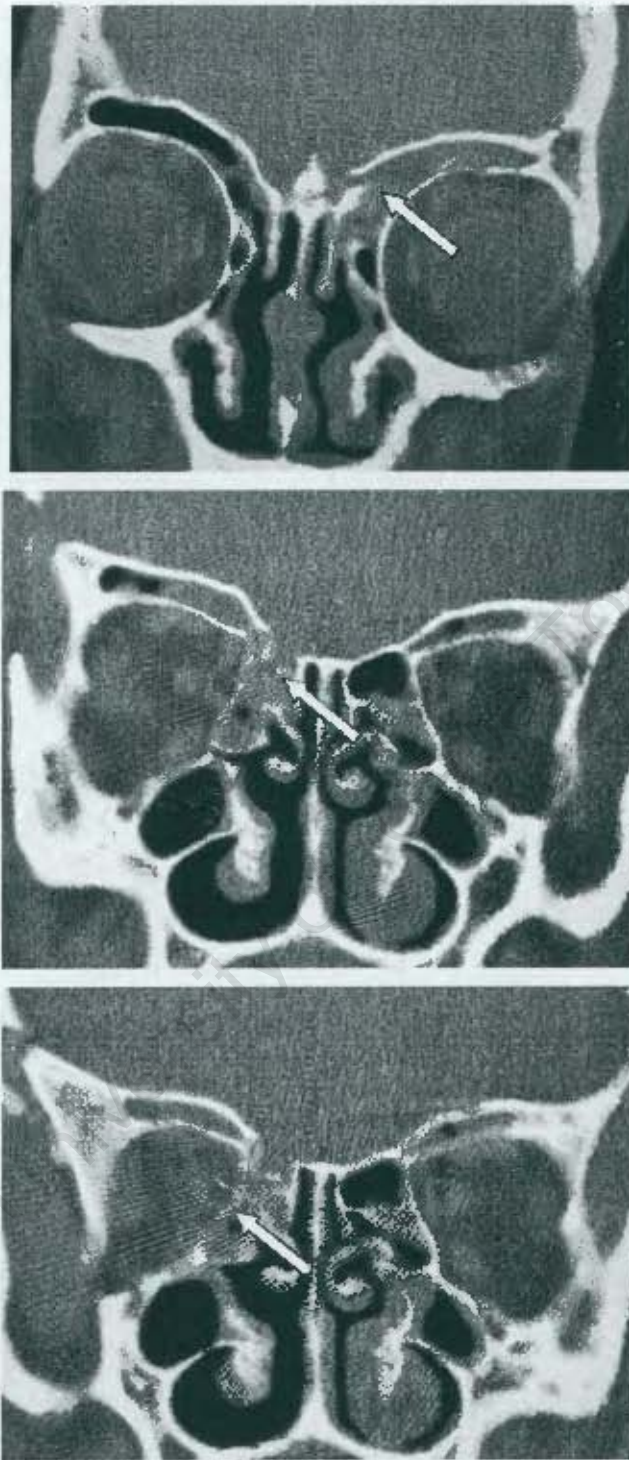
(C): Case 44. Following extraction of knife. Montage of 3 coronal CT slices (from anterior to posterior) of the anterior cranial fossa demonstrating the knife track (white arrow).
